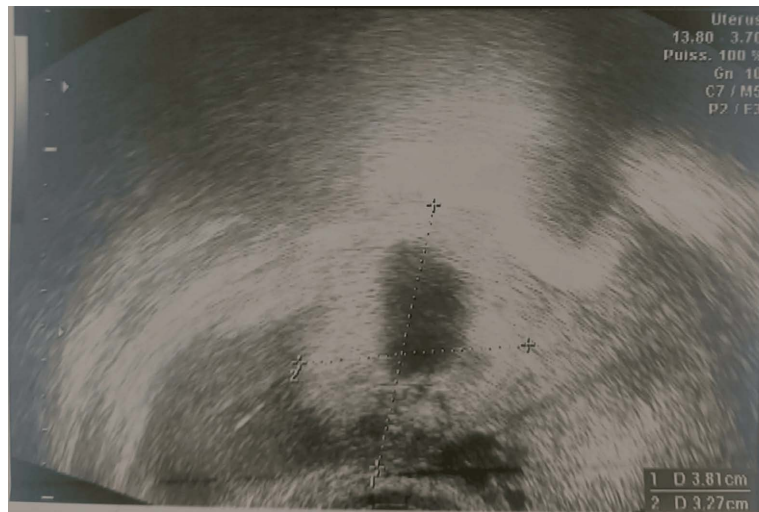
Pelvic ultrasonography image. The image demonstrates a heterogeneous left adnexal mass (lateral to the uterus) associated with signs of hemoperitoneum.
